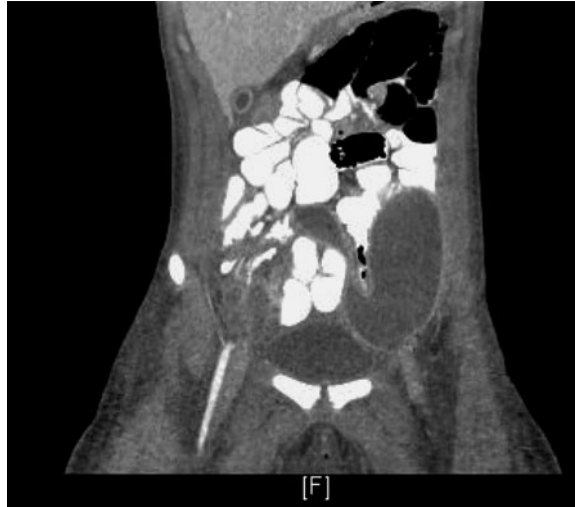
CT scan showing a large intra-abdominal abscess.
